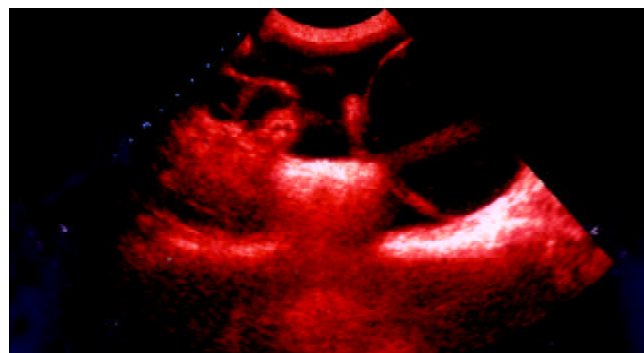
Transabdominal sonogram showed the adhesions between bladder and bowels, and the score is 4.
